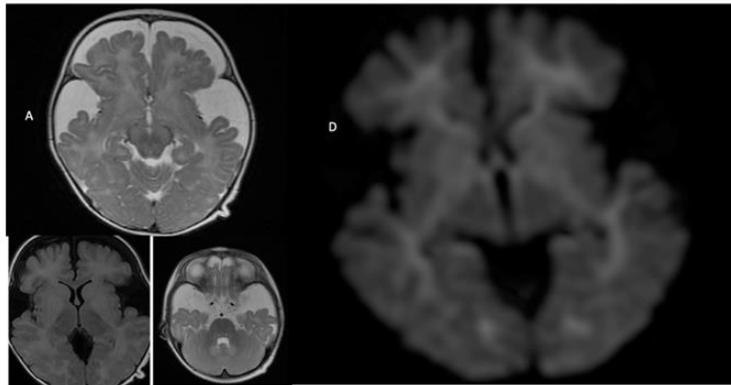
Axial MRI images in T2 (A, C), FLAIR (B) and DWI (D). They show diffuse abnormal hyperintense signal in the deep white matter, lentiform nuclei, caudate nuclei and dentate nuclei. Widening of the subarachnoid CSF spaces and anterior to the sylvian fissures. Corresponding hyperintensity on the DWI image.
